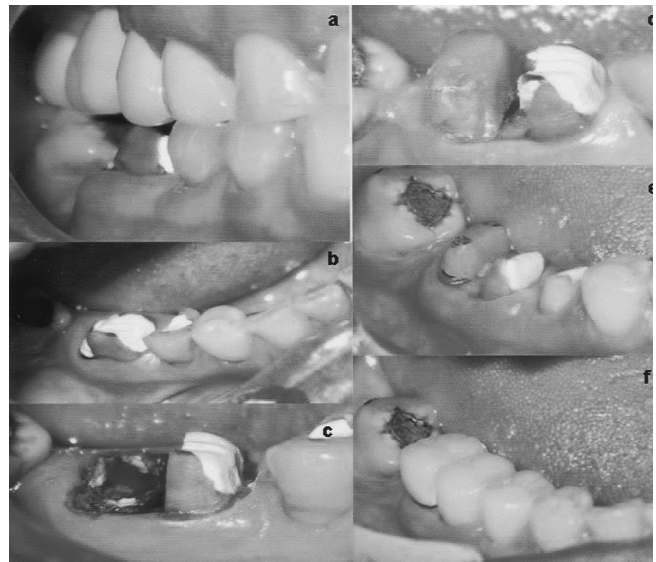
Vertical bone loss around the furcation area is shown by the radiographs. The canals were obturated and the chamber was filled. The tooth was separated. The fixed crown restorations involving each root and mandibular second premolar were cemented
